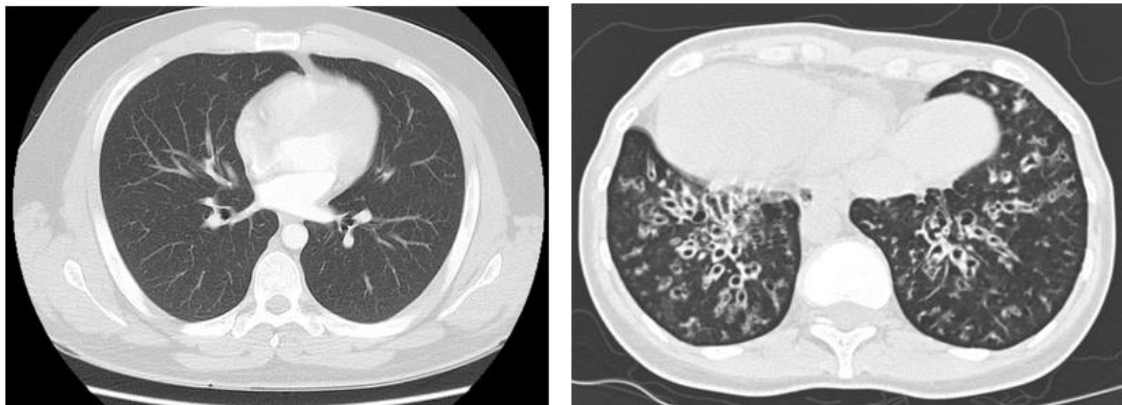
(left to right) apparently normal chest CT scan versus a CT scan of a patient with PCD^{70,71}
